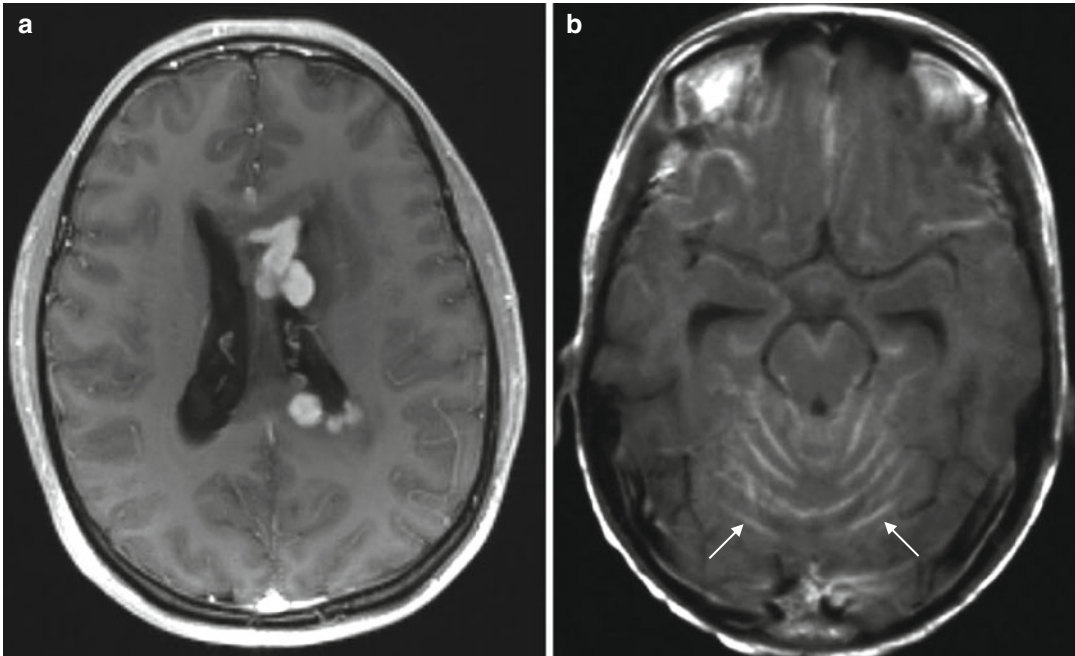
PCNSL on MRI. (a) Parenchymatous lesion with a typical localization in the periventricular space, intense and homogenous contrast enhancement, and a
